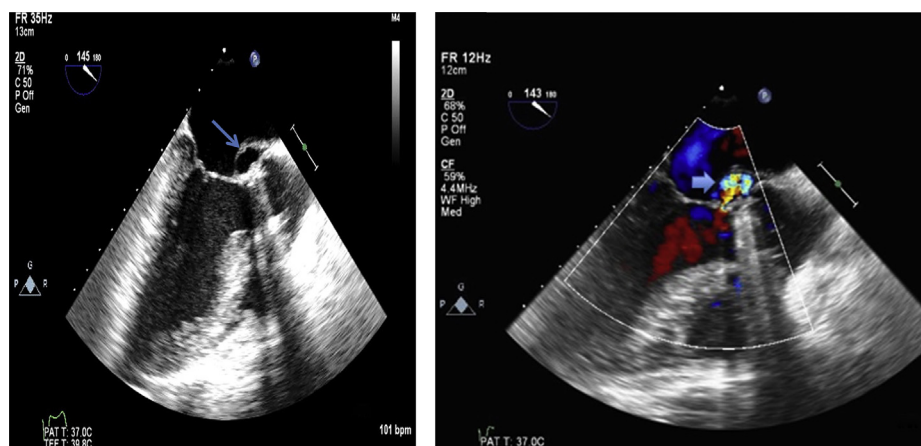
Transesophageal echocardiogram, midesophageal long-axis views without color (*left*) and with color (*right*), demonstrating P-MAIVF. Both images were obtained during systole and show the characteristic systolic expansion of the pseudoaneurysm (*arrows*). The color Doppler image demonstrates the pseudoaneurysm's communication with the left ventricular outflow tract (*thick arrow*). A mechanical prosthesis in the aortic position is present.
